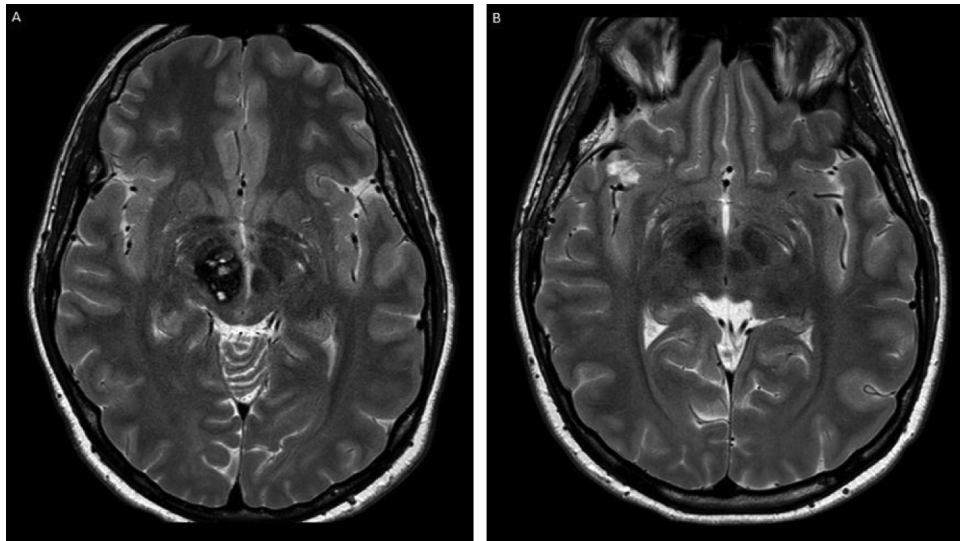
Patient 11: A. Preoperative T2-weighted MR image showing right red nucleus invaded by the BSCM. B. Postoperative T2-weighted MR image showing well individualized right red nucleus but surrounded by hemosiderin and presenting a fading of its physiological T2 hypo-signal compared to the other side.
